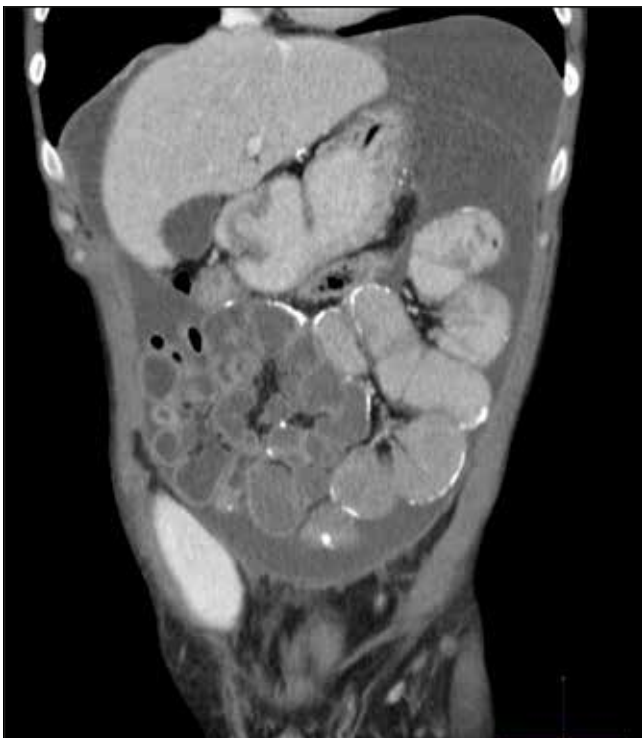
Coronal reformatted image from a CT scan of abdomen demonstrating a 'clump' of dilated central small bowel loops with serosal / peritoneal calcification in a patient with encapsulating peritoneal sclerosis. There is also a significant quantity of ascites.
